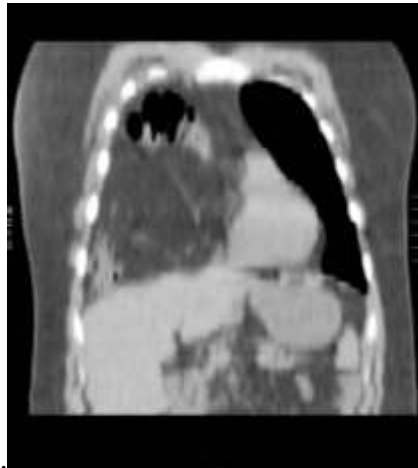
CT showed scans in coronal reconstruction-the loops of bowel and mesenteric fat herniated into the right hemithorax.
